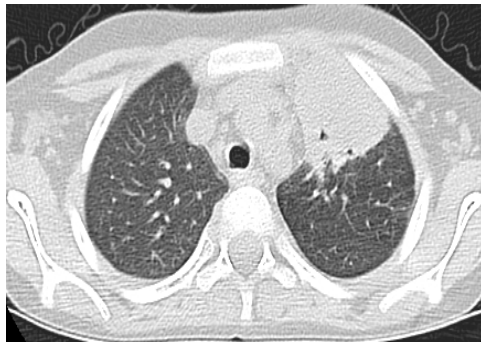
Chest CT 06.01.2014*
